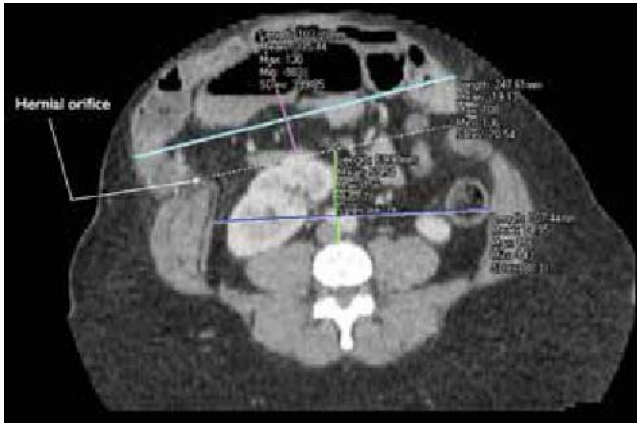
CT with axial reconstruction. Dotted white line represents hernia aperture. The blue line indicates the width, and the green line, the height of abdominal cavity. The light blue line indicates the width, and the purple line, the height of the hernia sac.
